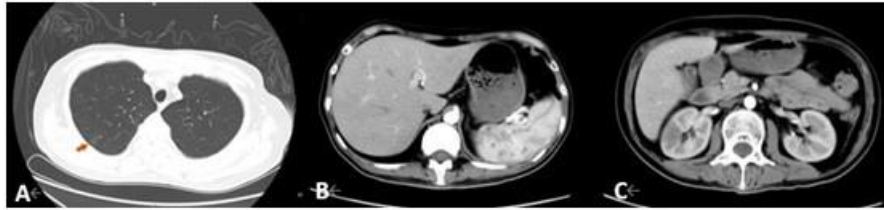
Lung and abdominal CT scans + 20 days after HSCT
